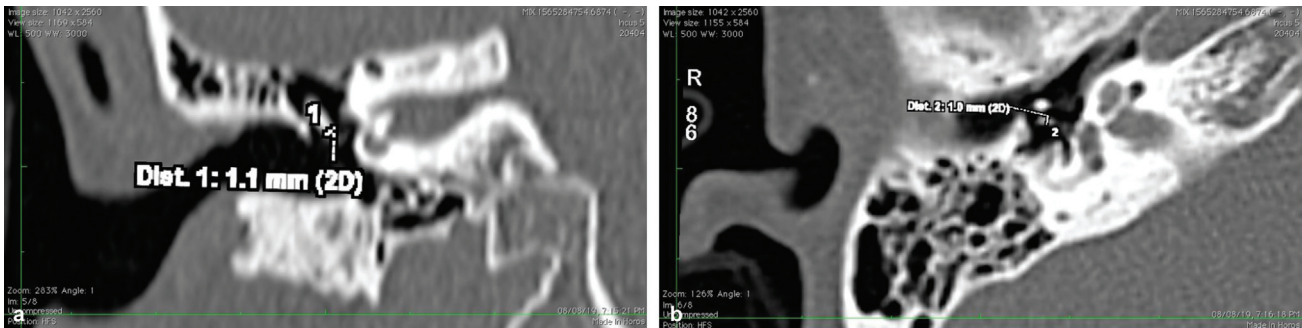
(a) Radiological measurement of the mediolateral diameter of LPI in the coronal section of HRCT. (b) Radiological measurement of Anteroposterior diameter of LPI in an axial section of HRCT
